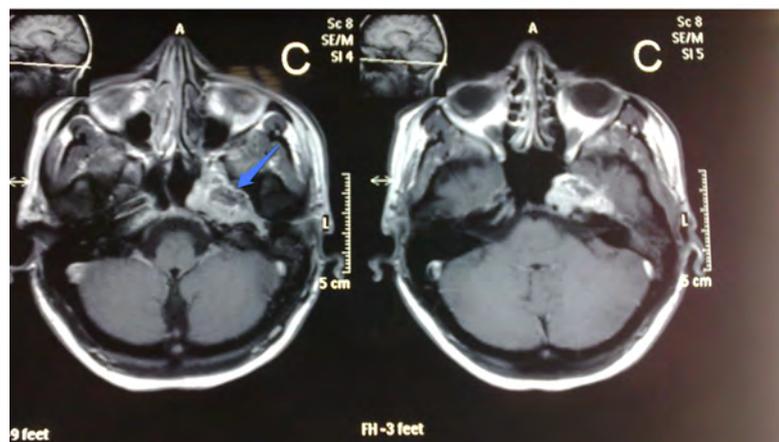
B)Follow up MRI of the treated glomus jugulare tumor
